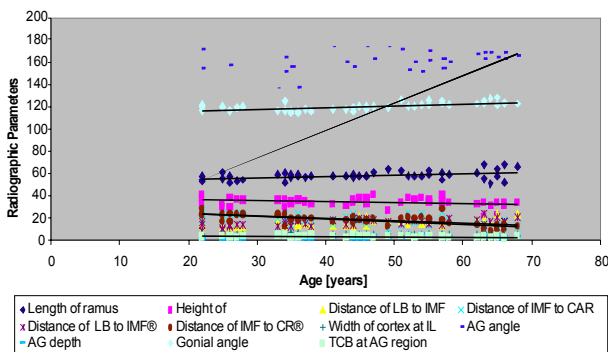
Radiographic parameters against age.
